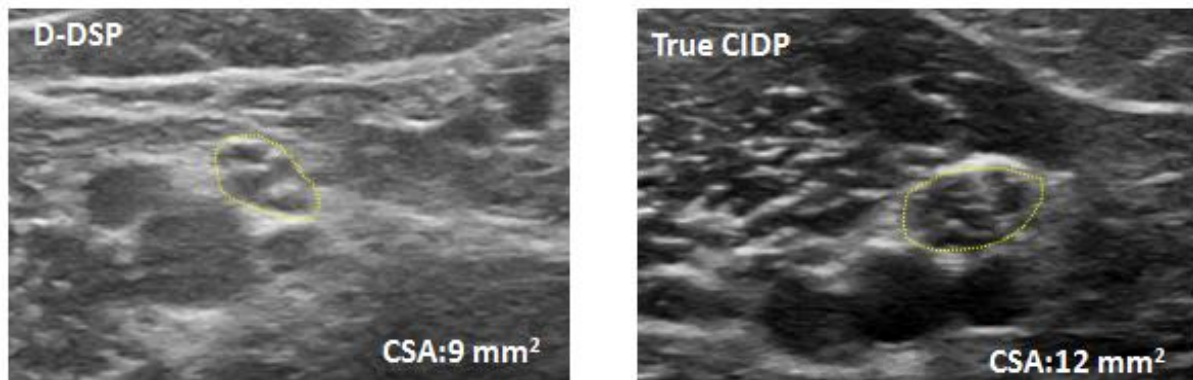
Sonogram images of the median mid arm of true CIDP patient versus D-DSP patients
